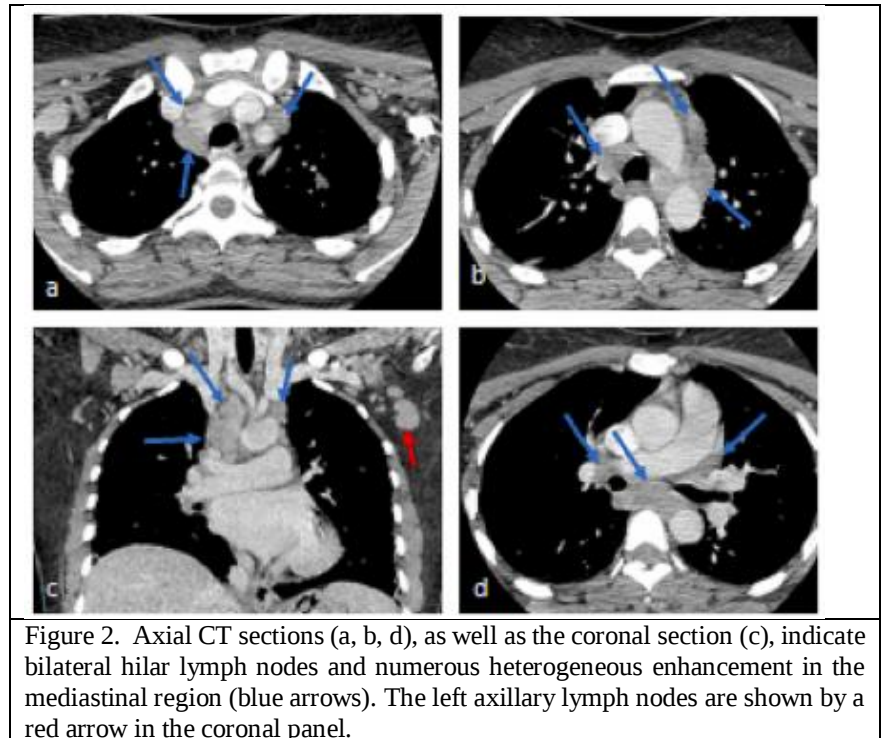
Axial CT sections (a, b, d), as well as the coronal section (c), indicate bilateral hilar lymph nodes and numerous heterogeneous enhancement in the mediastinal region (blue arrows). The left axillary lymph nodes are shown by a red arrow in the coronal panel.
